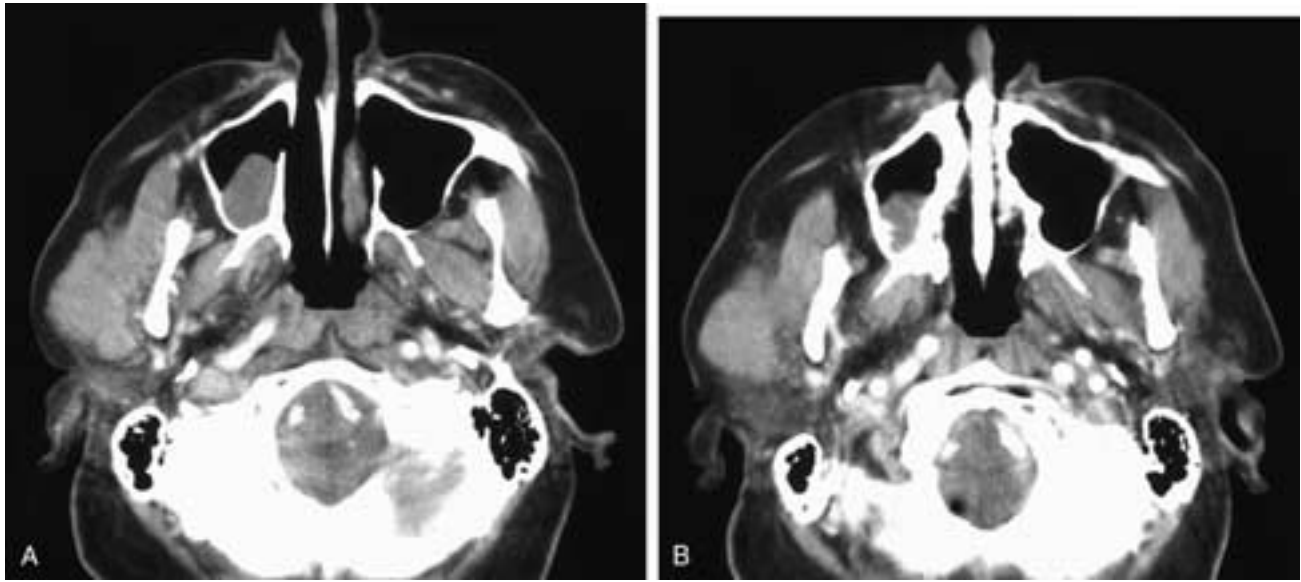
Axial contrast-enhanced CT scans (A and B) show a mass arising in the soft tissues overlying the right parotid gland. The tumor invades the parotid gland and the masseter muscle. Clinically, this was thought to be a parotid malignancy. This patient had a Merkel cell carcinoma.
